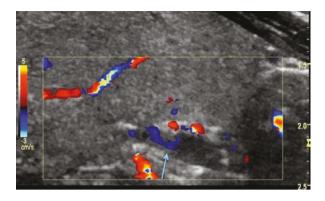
Ultrasound imaging with color Doppler showing a hypoechoic lesion posterior to the thyroid gland with a polar vessel sign (arrow)
